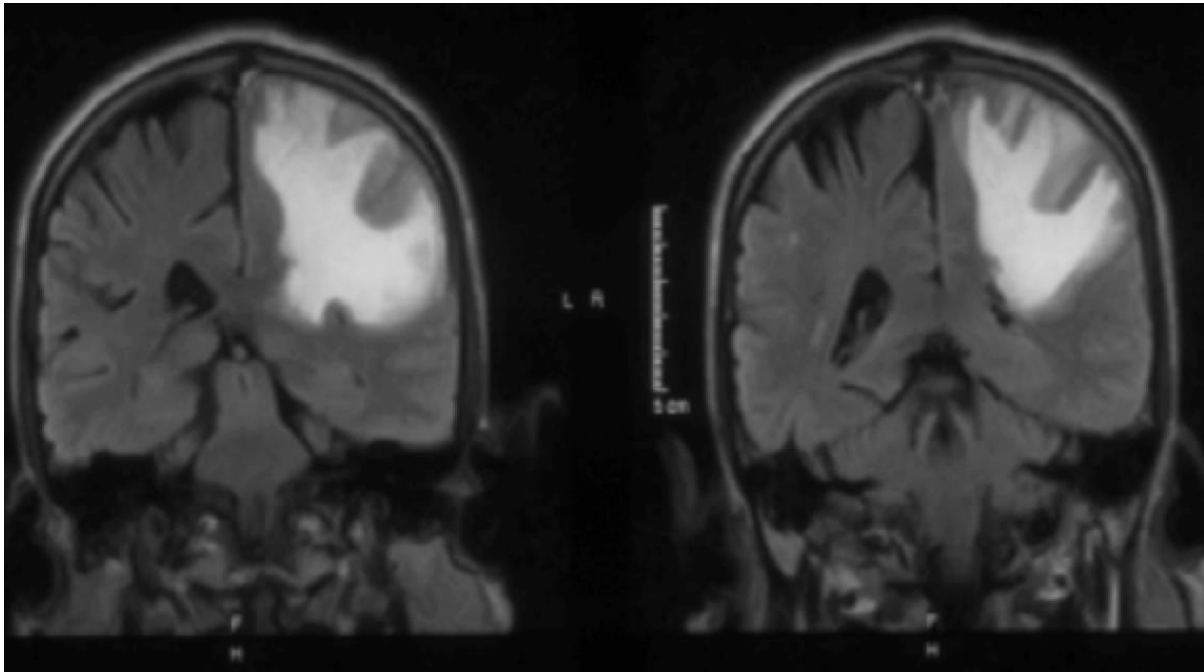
MRI on coronal plane of FLAIR sequence, showed extensive infiltrative edema within the superficial and deep white matter tract of the left fronto-parietal lobes involving the genu and body of the left corpus callosum compressing onto the ipsilateral lateral ventricle without crossing the midline. Cortical grey matter swelling noted as evident by effacement of the sulci and gyri.
